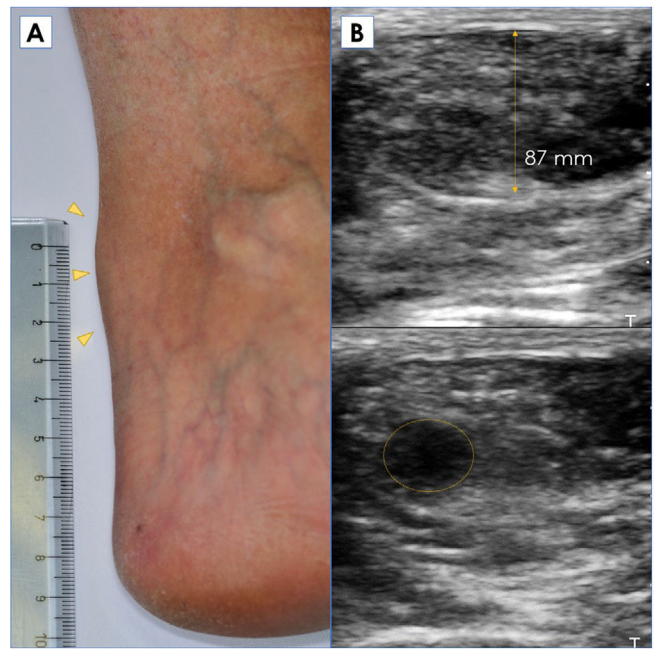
Panel A – Physical examination of Achilles tendon xanthomas (arrowhead). Panel B – Achilles tendon ultrasonography with increased thickness and irregular hypoechoic region (circle).
